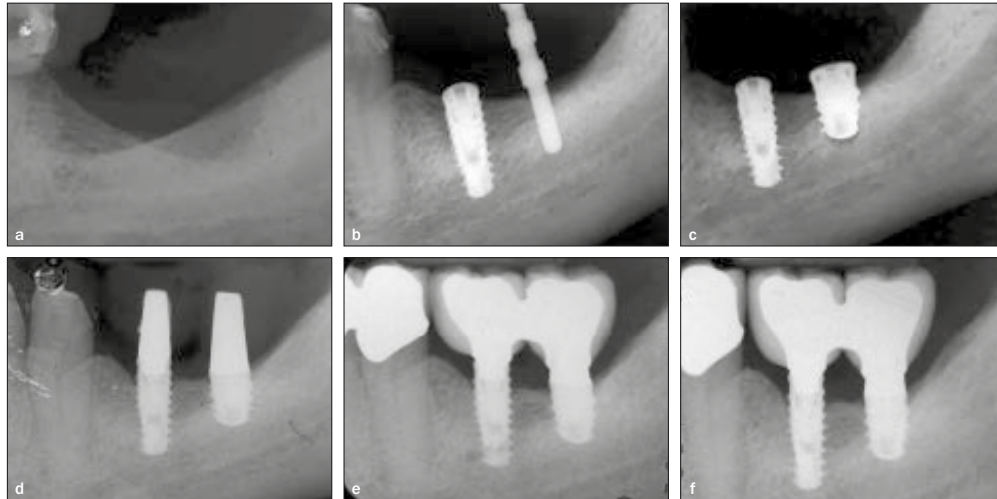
Radiographs (a) before surgery, (b) with paralleling pin, (c) after surgery, (d) at baseline with provisional restoration, (e) at 1-year follow-up, and (f) at 3-year follow-up.
